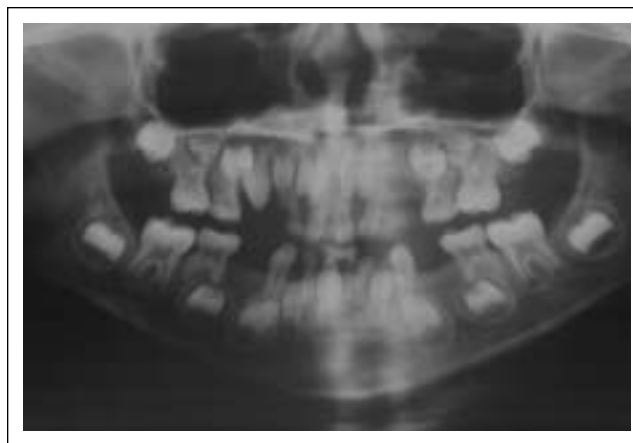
Panoramic radiograph showing the dental agenesis.
